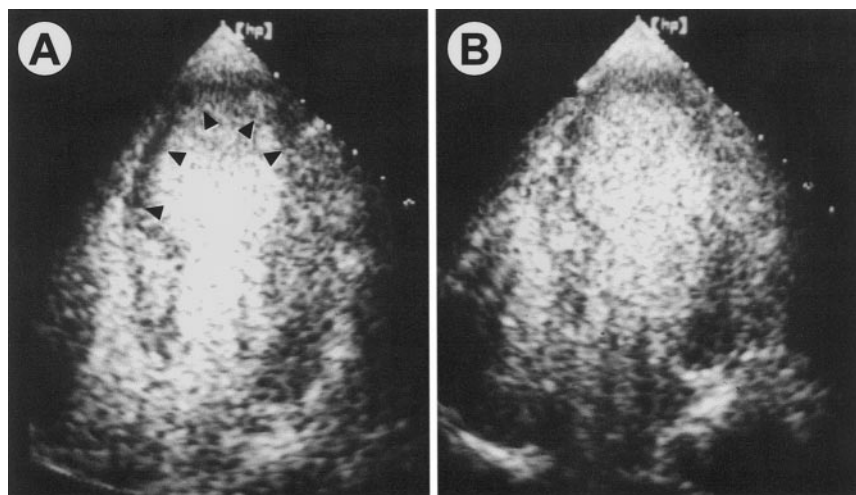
MCE at end systole (apical 4-chamber view) in patient with anterior AMI before PTCA (A) and 24 hours later (B). Sum of endocardial border length corresponding to risk region in 2- and 4-chamber views was measured as 13.8 cm before PTCA and 3.9 cm after 24 hours ("no-reflow" region). Ratio to risk region of 28% indicated significant reduction of perfusion defect (arrows).
